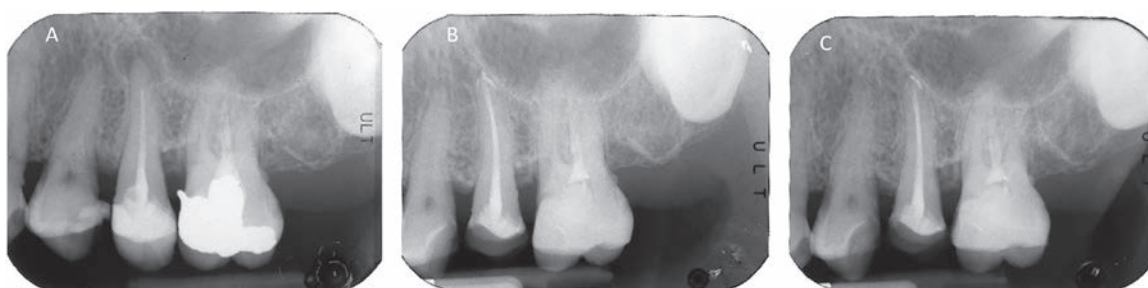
(A) A preoperative radiograph of a maxillary first premolar with a periradicular lesion. (B) A postoperative radiograph of tooth underwent apical surgery. (C) The radiograph taken at the 2-year recall exhibits a complete resolution of the periradicular endodontic lesion. The tooth is classified as healed.
